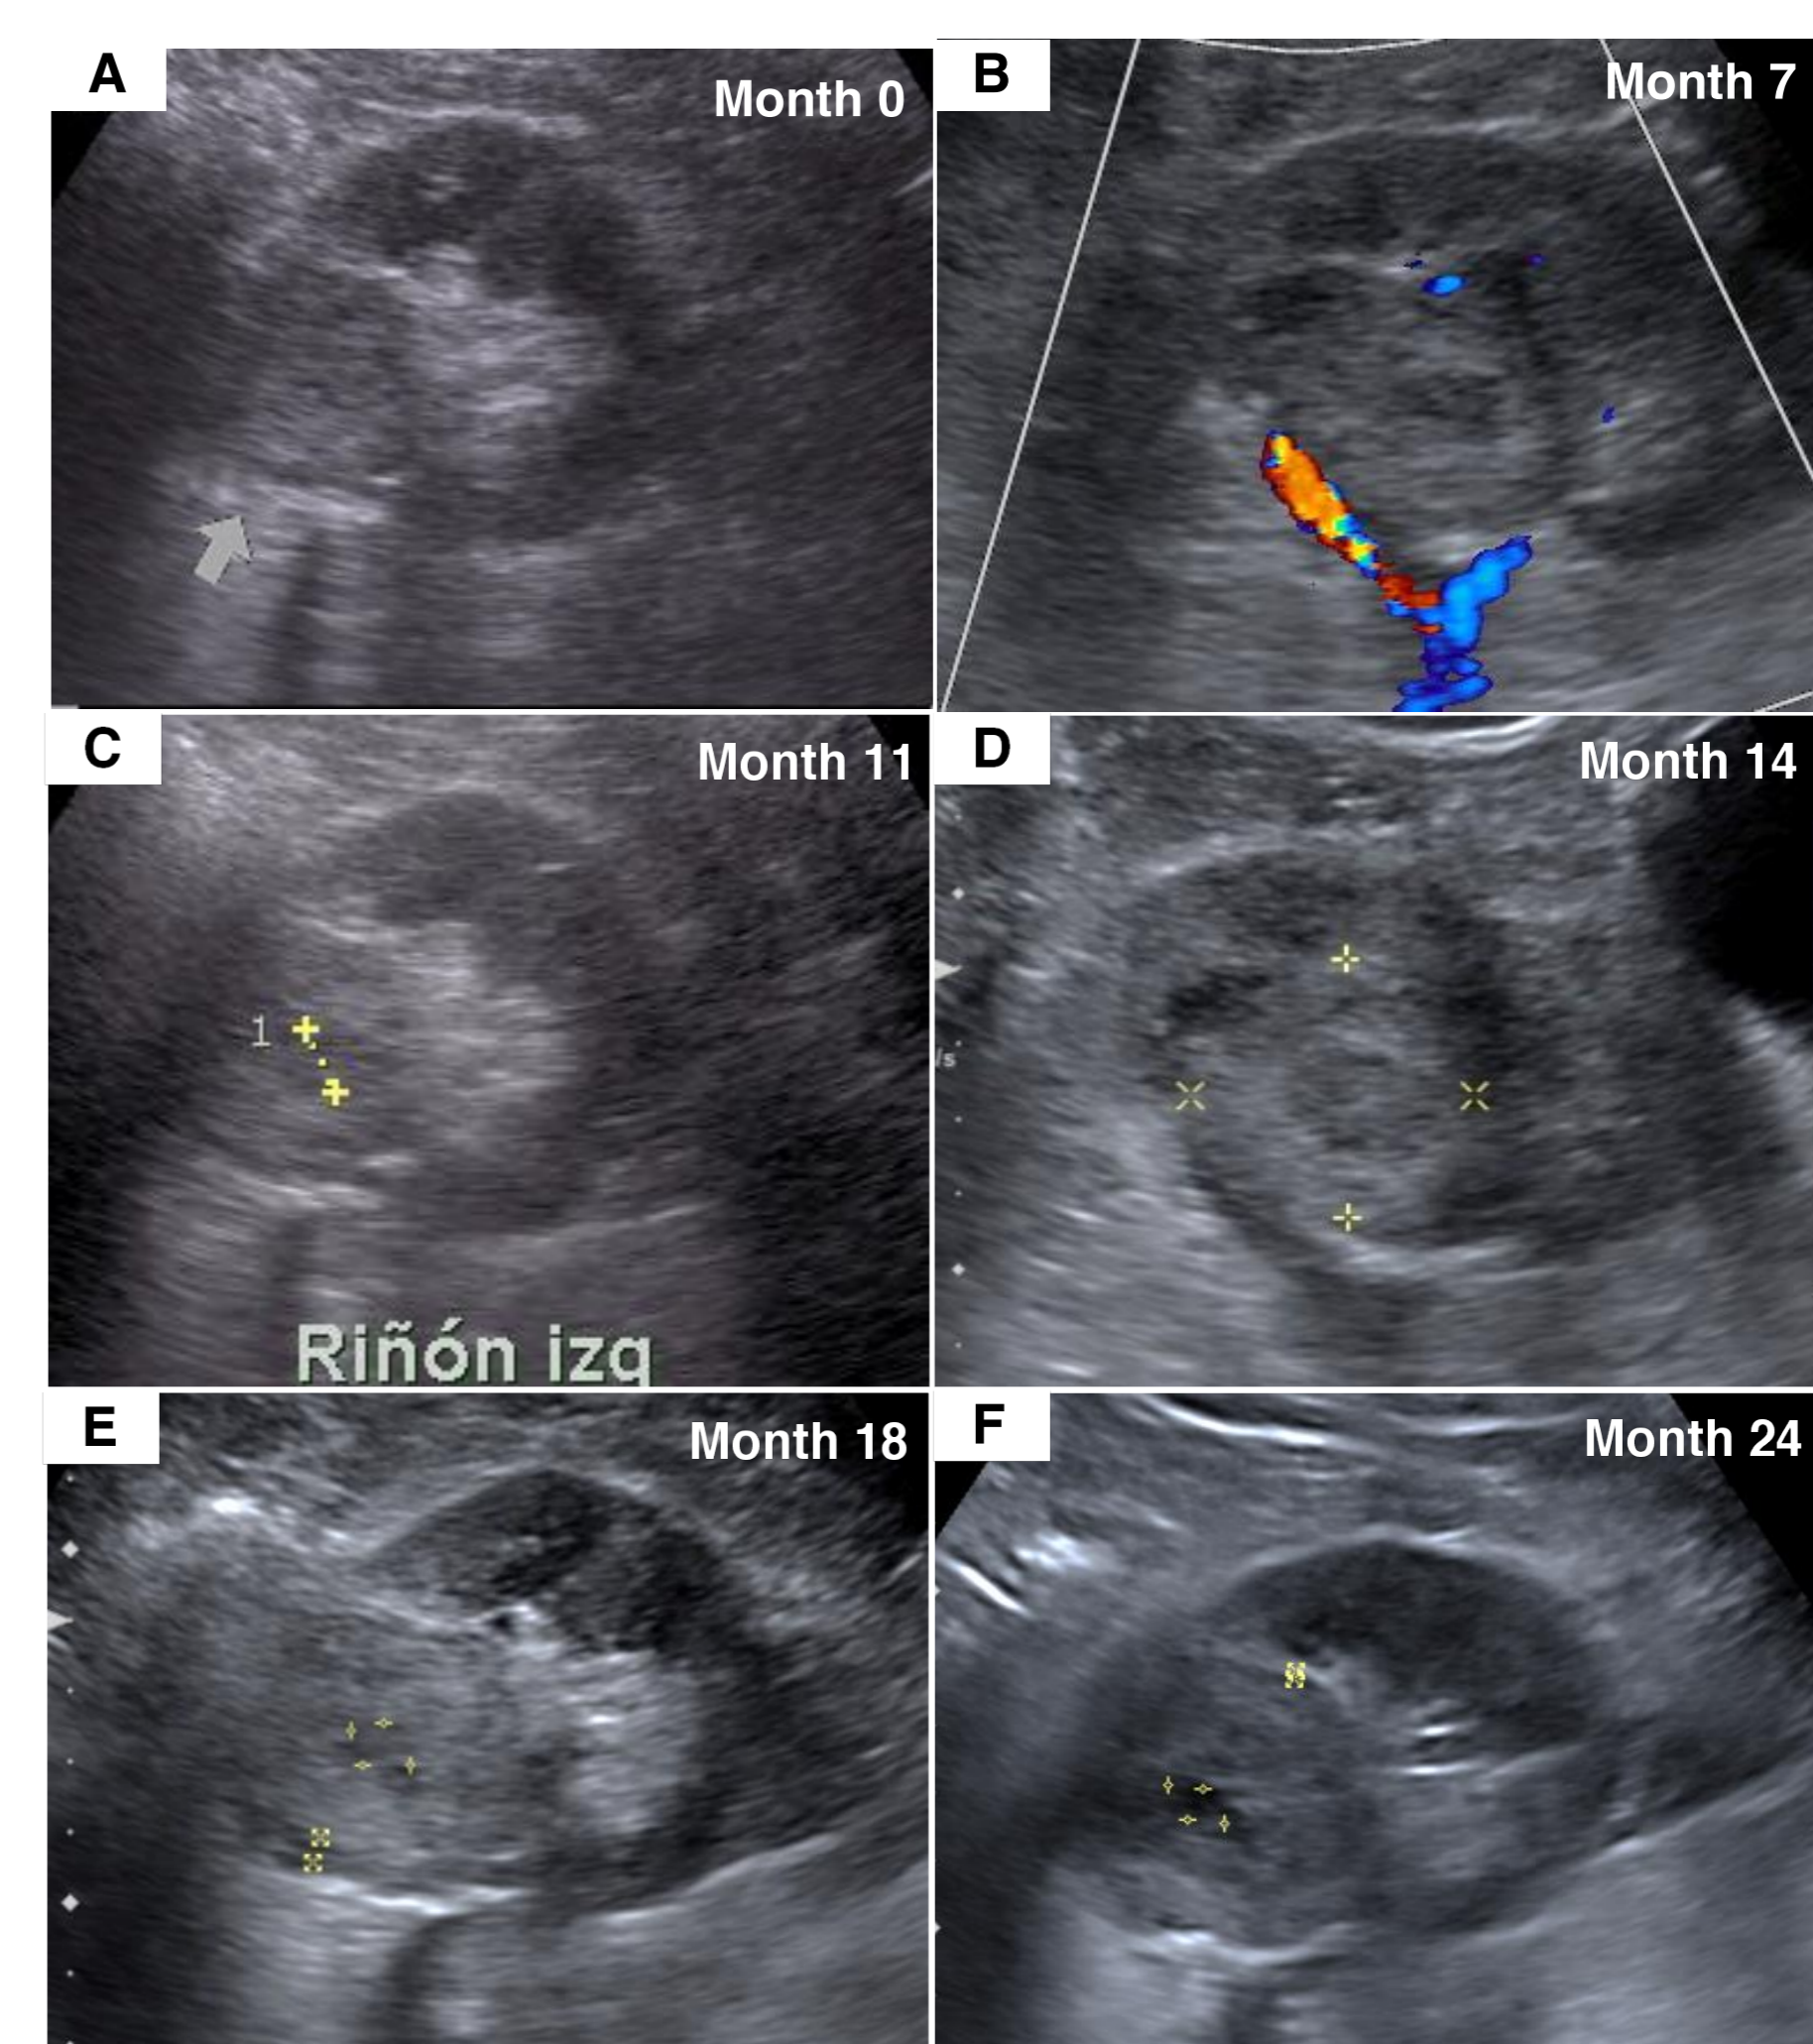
Kidney ultrasound evolution of the clear cell RCC patient during 24 months of VAE treatment. A peritumoral and necrotic area were observed from month 7 until month 24 (last follow-up). A-B: ultrasound from month 0, 7, 11, 14, 18, 24 respectively.
